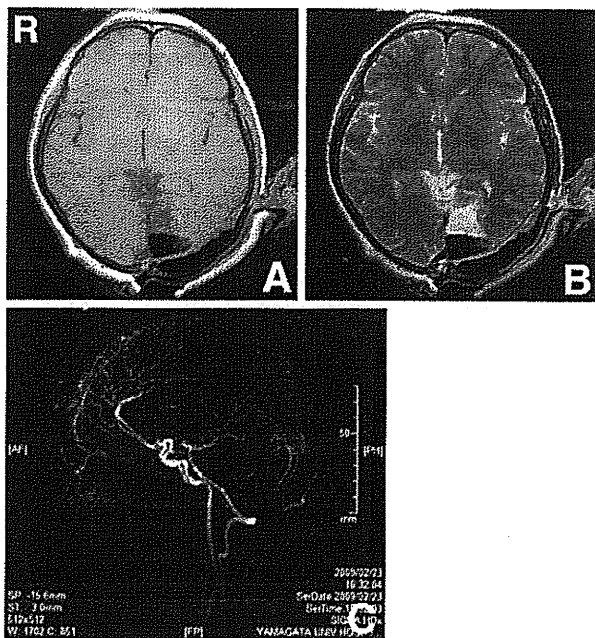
Intraoperative T₁-weighted (A) and T₂-weighted (B) magnetic resonance images, and time-resolved imaging of contrast-kinetics image (C) showing complete removal of the arteriovenous malformation.
